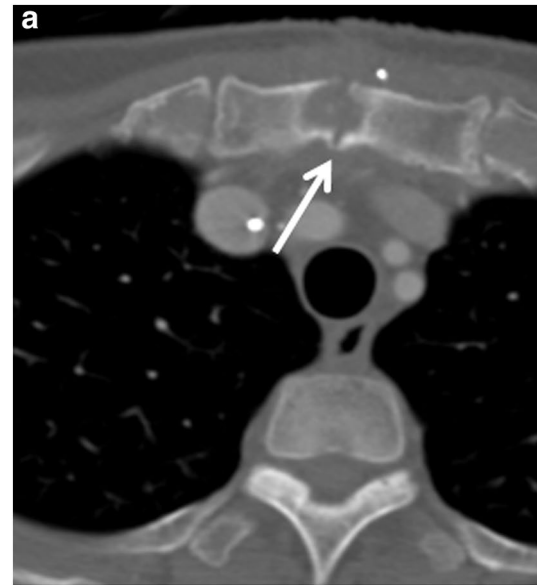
Deep sternal wound infection in a 60-year-old woman who underwent mass excision of cardiac myxoma. a Axial bone window setting CT image shows ovoid osteolytic bone destruction (arrow) in sternotomy of manubrium, suggestive of osteomyelitis. b Axial mediastinal window setting CT image reveals ill-defined ovoid soft-tissue density mass (arrowhead) in anterior portion of osteolytic bone destruction and thickening of adjacent skin
